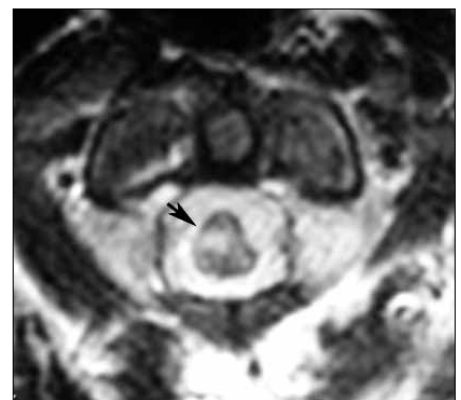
Postoperative cervical MRI (C1-C2) shows the lesion.
